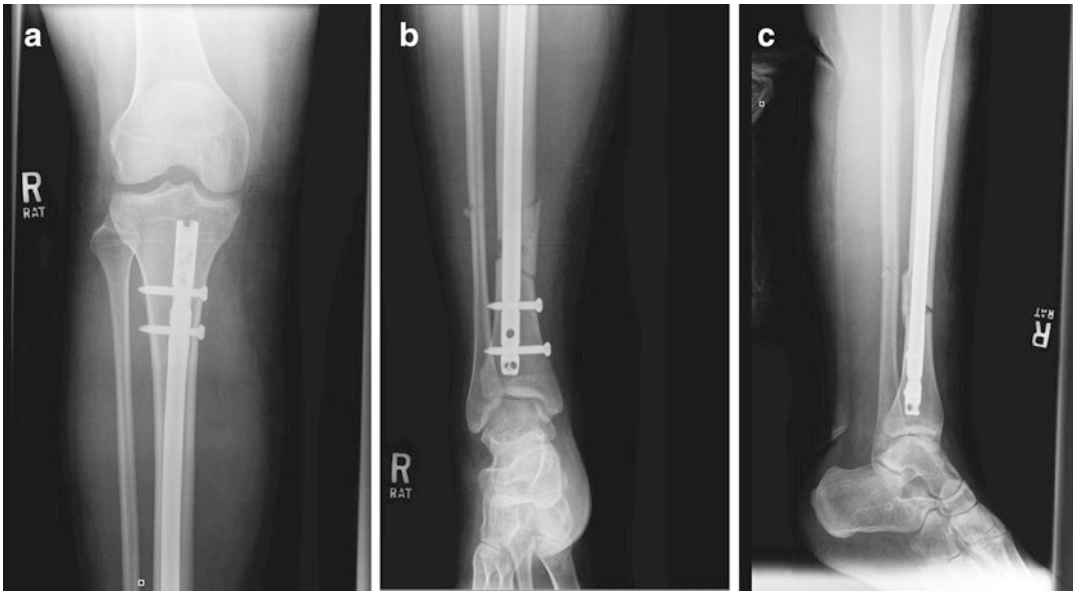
(a, b) AP radiograph tibia. (c) Lateral radiograph tibia
